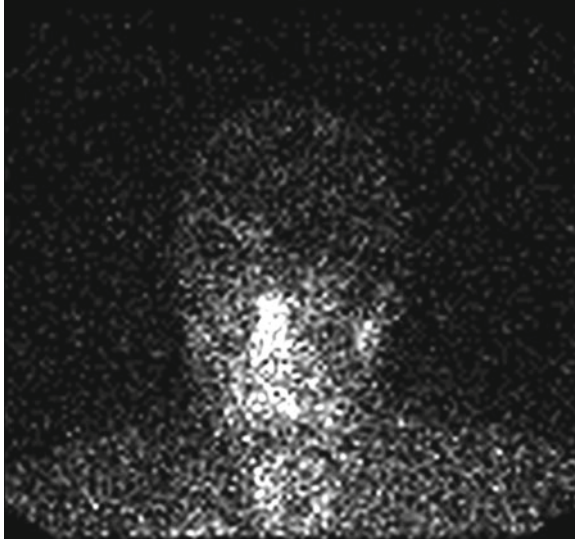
One patient SPECT scan
